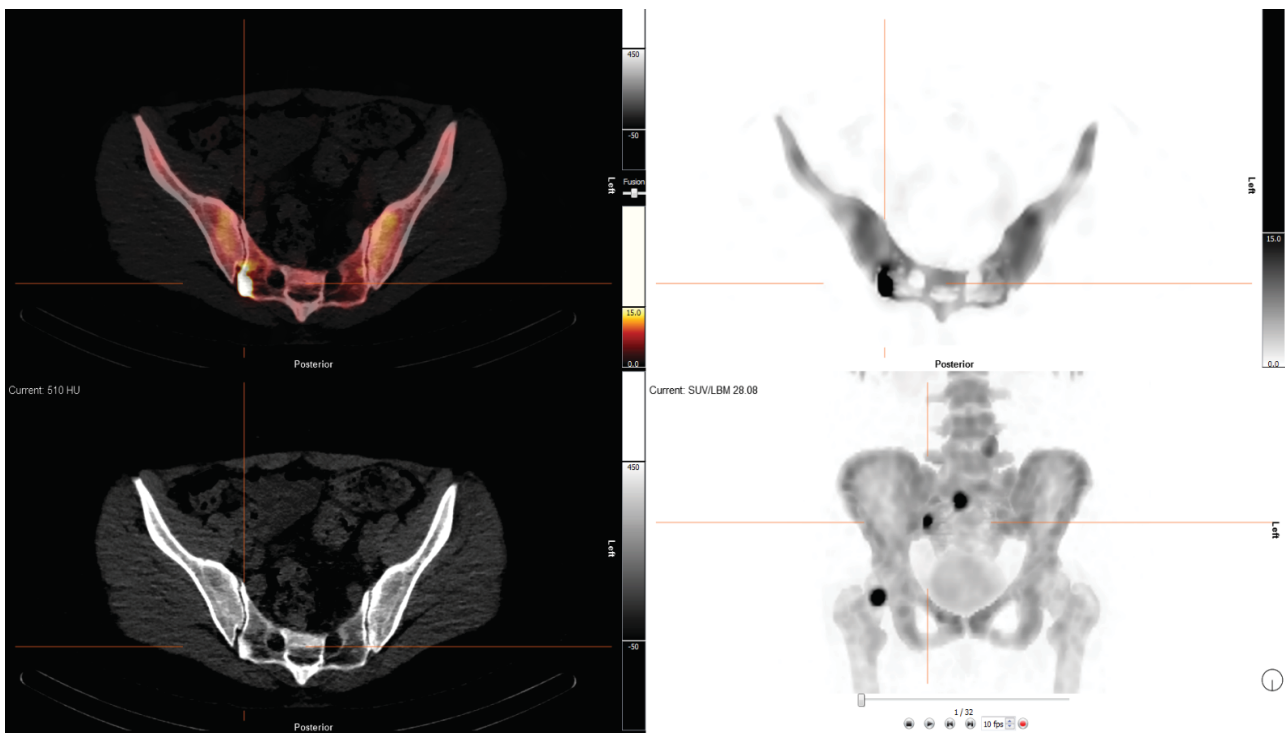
Case 1: SPECT images, CT images and SPECT/CT image (metastases, SUV/LBM max 28.08)
